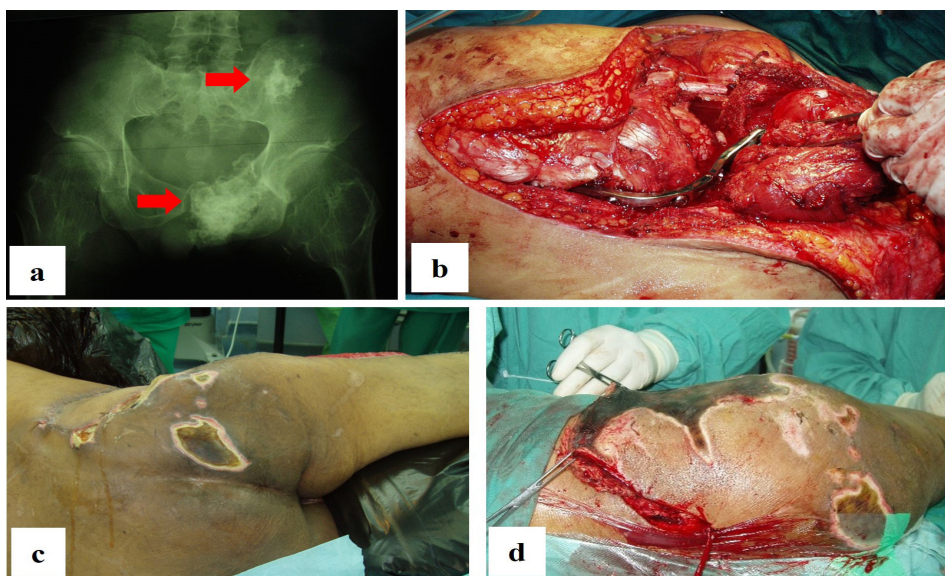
In Case #2, the patient had recurrence of left pelvic chondrosarcoma. Plain radiograph showed involvement of the ischiopubic region and ilium, indicated by the red arrows; (a) This led to the decision for an internal hemipelvectomy with hip arthrodesis using plate and screws; (b) However, he subsequently developed chronic wound infections and dehiscence, necessitating multiple debridement; (c & d) which eventually resulted in the decision for an external hemipelvectomy
